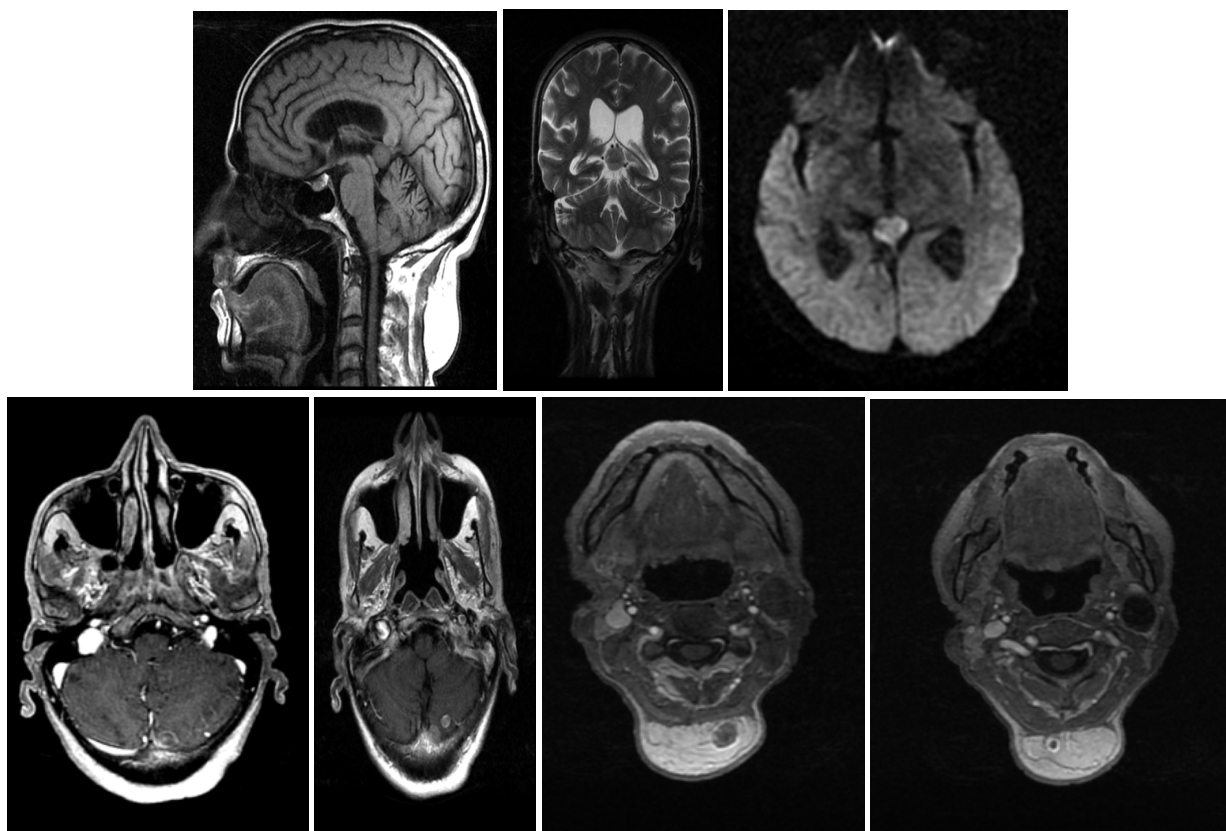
Brain MRI showing: An extra-axial lesion centered on the pineal gland (yellow arrow), oval in shape, well limited, with lobulated contours, described in T1 isosignal (a), T2 isosignal (b), diffusion restrictive (c), heterogeneously enhanced after contrast (d), secondary in appearance. Presence of two left cerebellar hemispheric nodular lesions (blue arrow) (e,f), annularly enhanced after contrast, secondary in appearance. Multiple nodular tissue lesions in the nuchal region (red arrow), roughly rounded, heterogeneously enhanced after contrast, related to permeation nodules. These lesions are located with a lipomatous formation resting on the trapezius muscle containing a few thin non contrast-enhanced septa measuring 62 mm in diameter.
